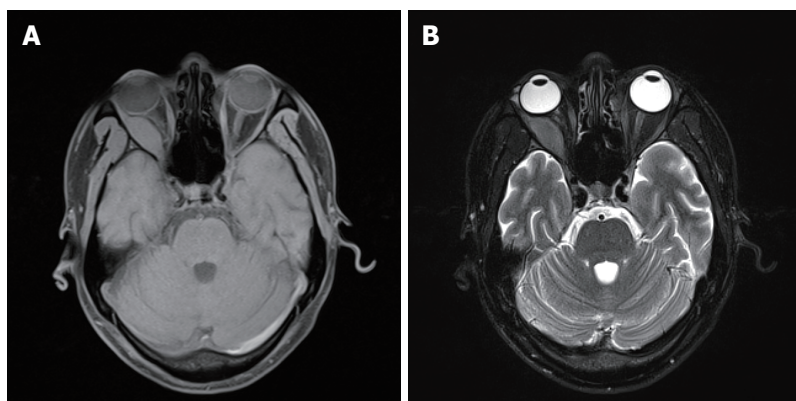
The results of T1-weighted (A) and T2-weighted (B) magnetic resonance imaging scans of the orbit show a uniform signal-intensity mass in the right lateral rectus area and right optic nerve compression with displacement.
